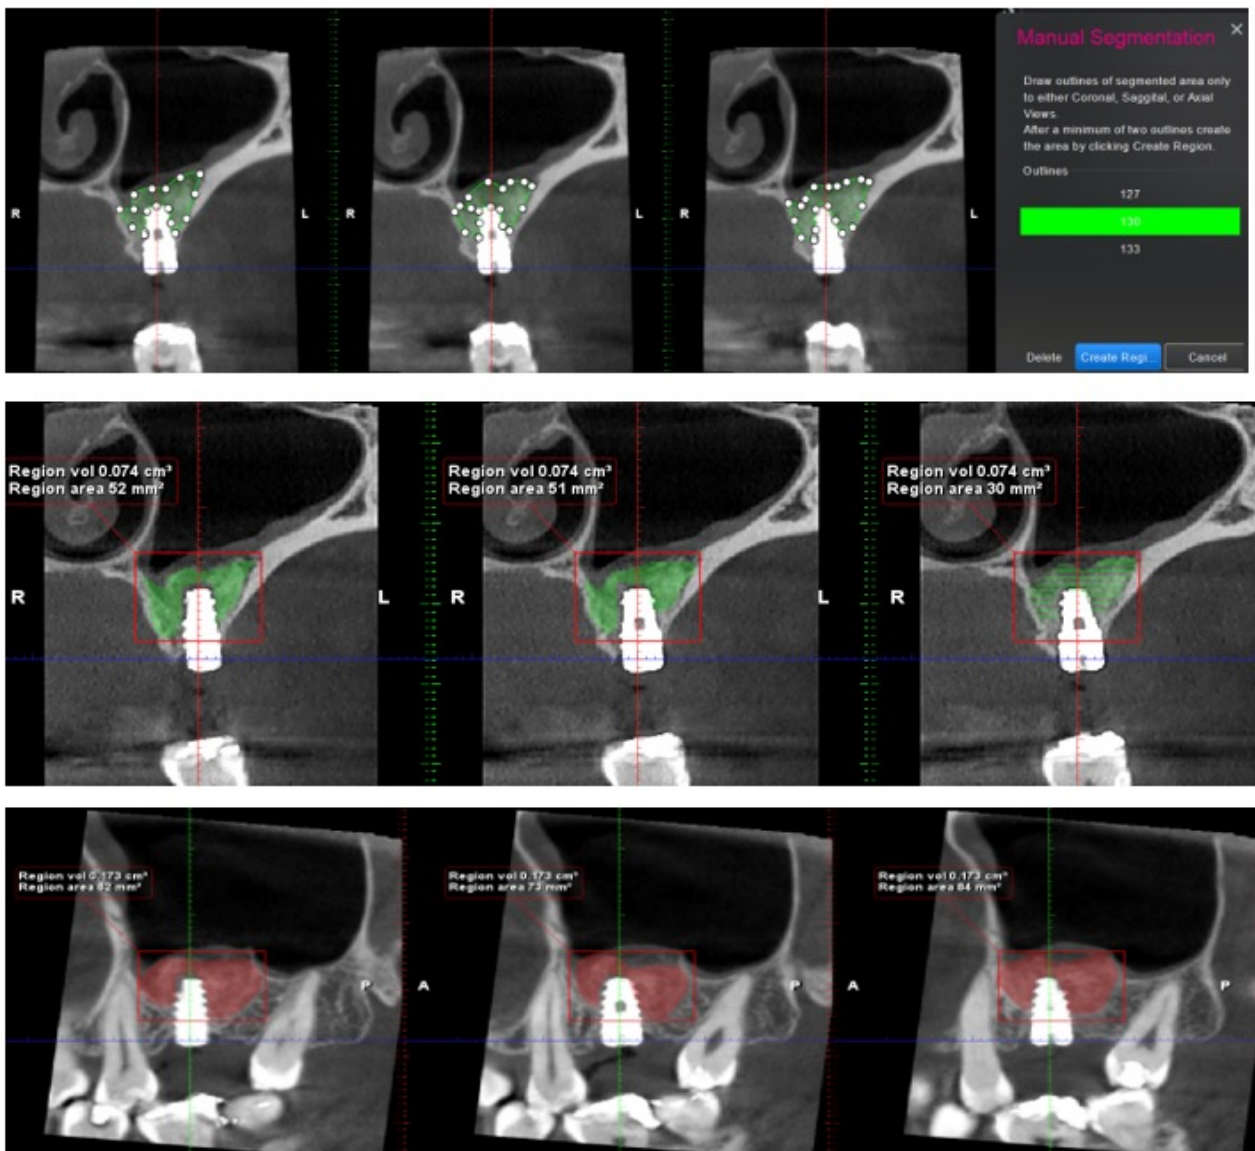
CBCT segmentation example (coronal and sagittal slices and segmented endo-sinus volume).
